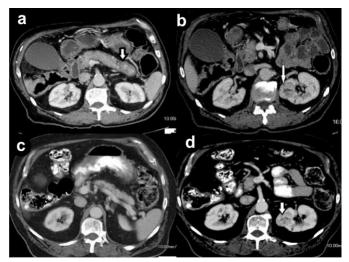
a) Contrast enhanced axial CT of the abdomen shows enlarged pancreas with loss of normal fatty lobulation. There is a hypodense "halo" or capsule (white arrow) around the pancreas. b) Contrast enhanced axial CT of the abdomen showing a well circumscribed solid heterogonous renal mass measuring 30 X 26 mm in the mid pole of the left kidney. c) Contrast enhanced CT of the abdomen 5 months later showing resolution of pancreatitis and a normal appearing pancreas. d). Contrast enhanced CT scan 5 months later showing the enlarging renal mass 34 x 30 mm.
